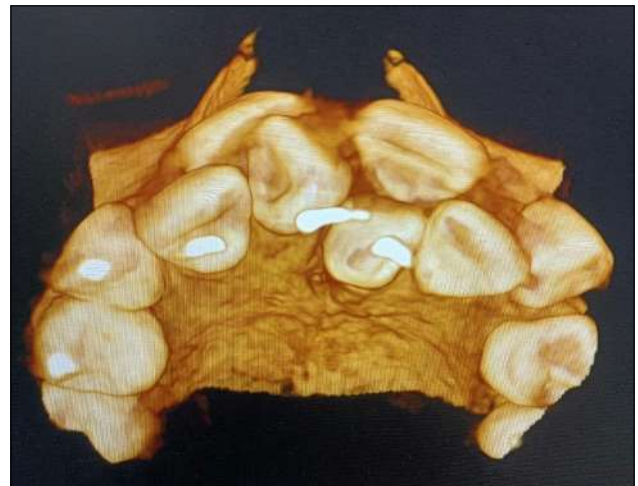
CBCT showing mesiodens causing impaction of 11 also one mesiodens presents palatally to 21
